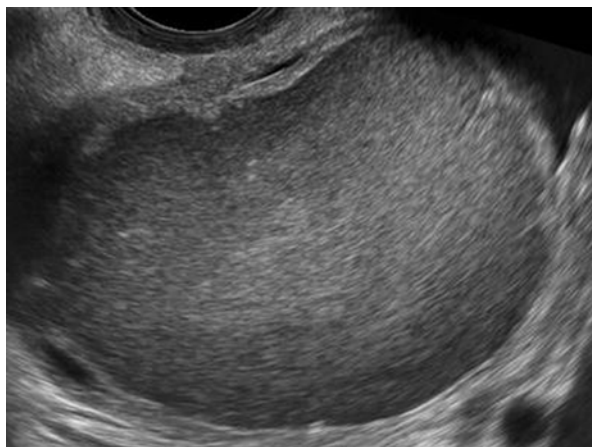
Endometrioma by transvaginal ultrasound (Reprinted from Coccia et al. [74], Figure 3, with kind permission from Springer Science and Business Media)
